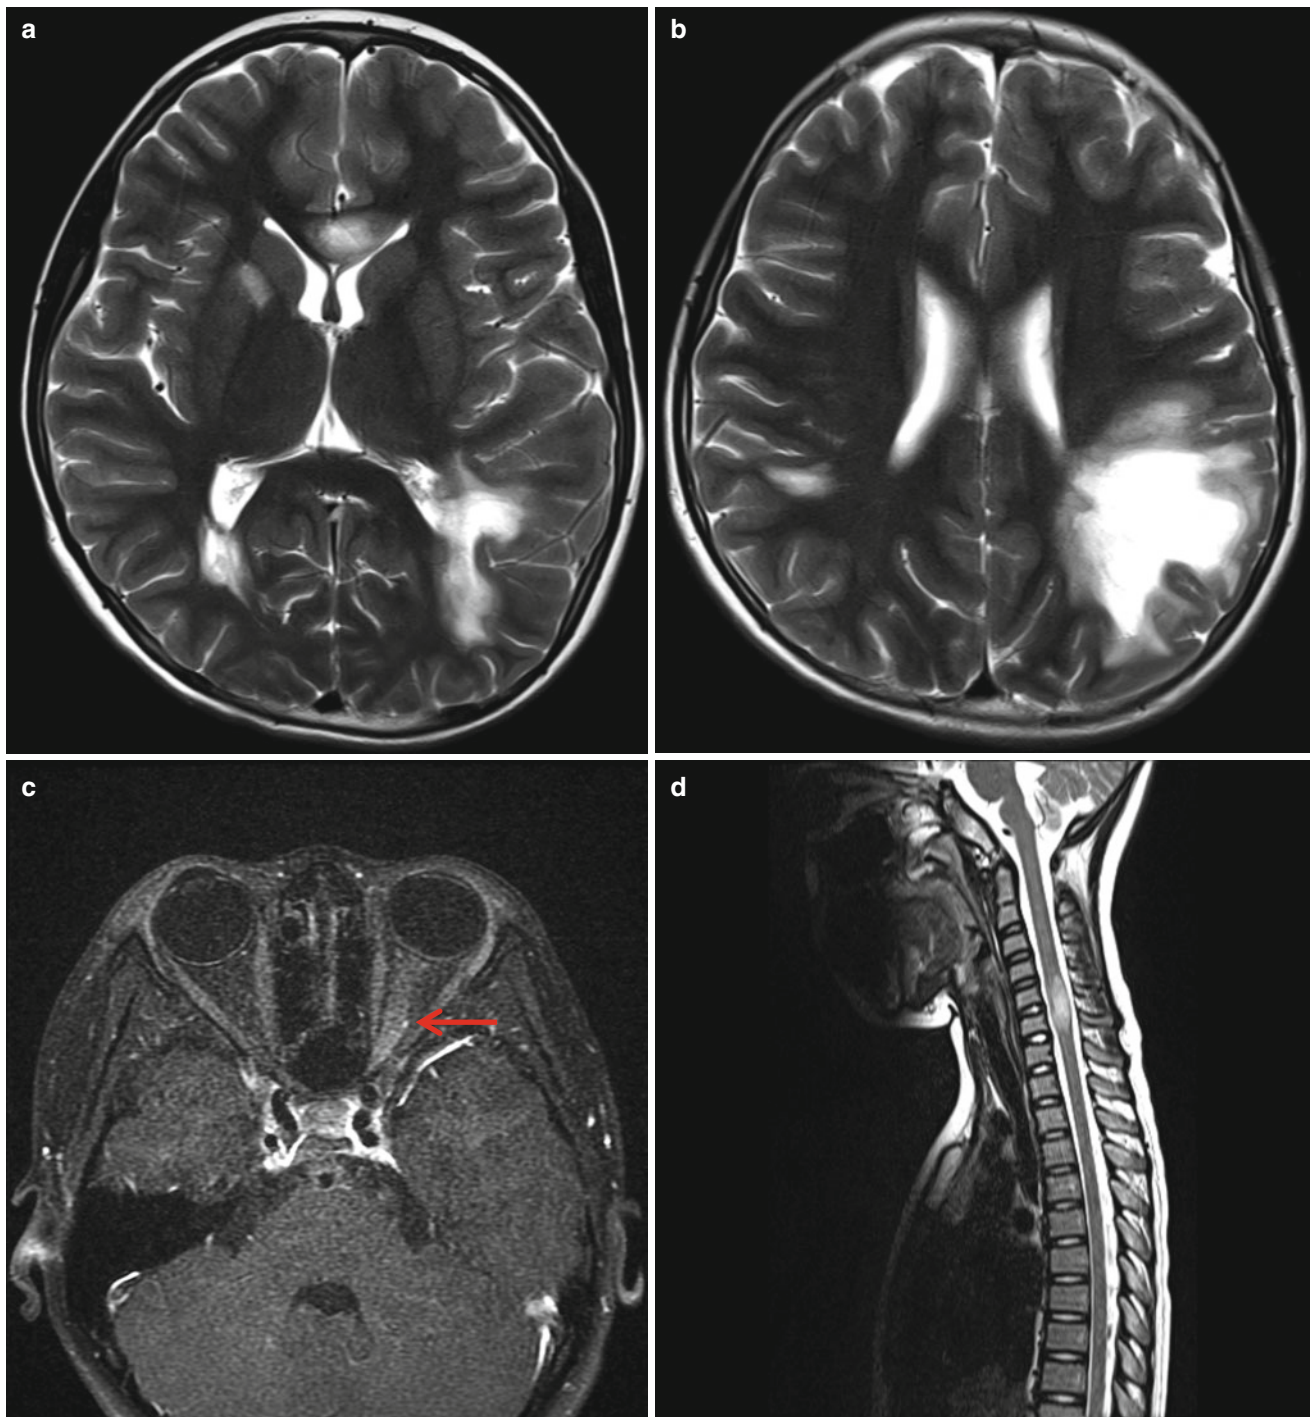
Multiple sclerosis in a 9-year-old-girl with optic nerve and spinal cord involvement. (a) T2-weighted image shows multifocal white matter lesions including the corpus callosum and right internal capsule. (b) Periventricular and deep white matters are also involved.
